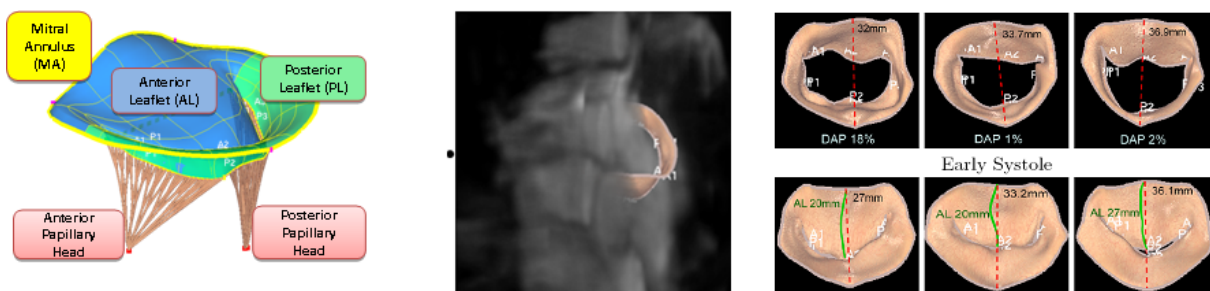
Left. Mitral Valve model extended with subvalvular structures. Middle. MV model fitted into MRI data. Right. Automatically derived model-base MV measurements
